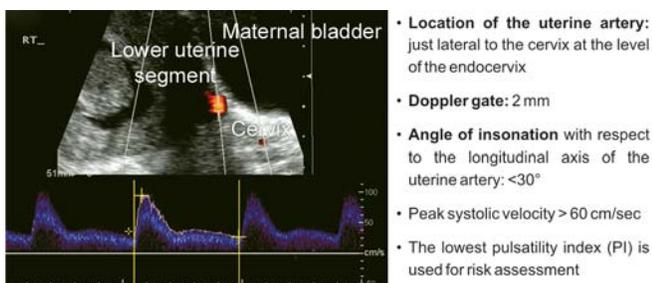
Pulsed Doppler evaluation of the uterine artery [pulsatility index (PI) measurement]
